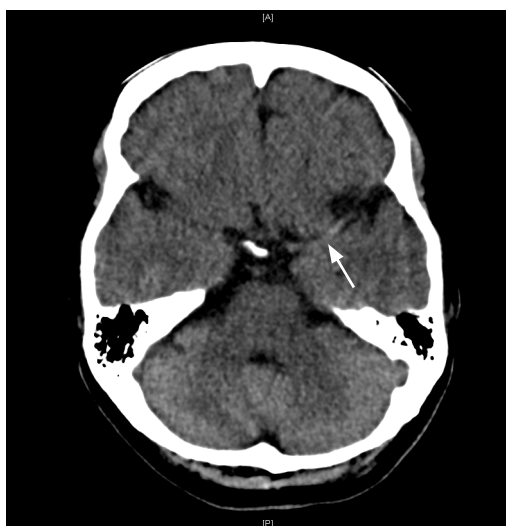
Computed Tomography Brain (non contrasted) showing a dense MCA sign (arrow)
